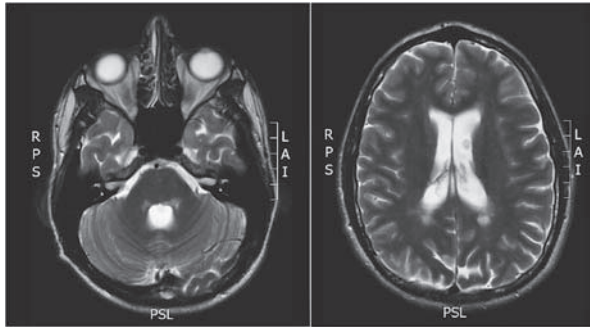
Brain magnetic resonance imaging: T2 sequences of the patient with multiple sclerosis who presented with double vision. Left figure shows demyelinating lesion present in the brainstem, Right figure shows multiple periventricular lesions.
